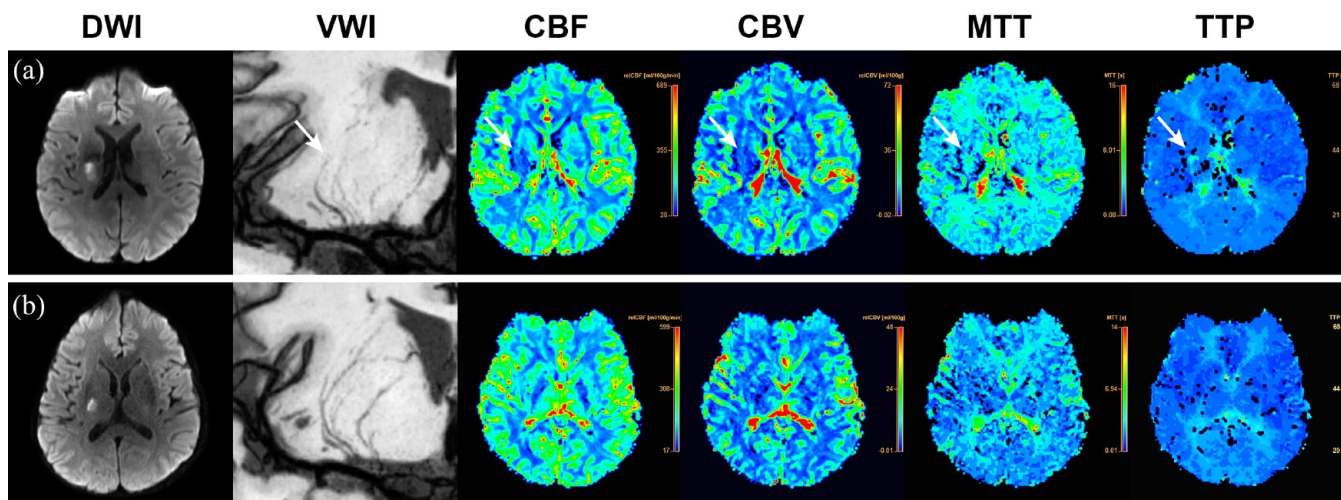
Two representative examples of the perfusion patterns. (a) Hypoperfusion: acute single subcortical infarction (SSI) in the right basal ganglia on diffusion-weighted imaging (DWI) with reduced cerebral blood flow (CBF) and cerebral blood volume (CBV), and prolonged mean transit time (MTT) and time to peak (TTP) (white arrows). The reconstructed coronal minimum-intensity projection (MinIP) of vessel-wall magnetic resonance imaging (VWI) showed shorter lengths of the right lenticulostriate arteries (white arrow). (b) Normal perfusion: acute SSI in the right basal ganglia on DWI without perfusion defects. The coronal MinIP of VWI revealed almost normal lenticulostriate arteries in the ipsilateral right hemisphere.
